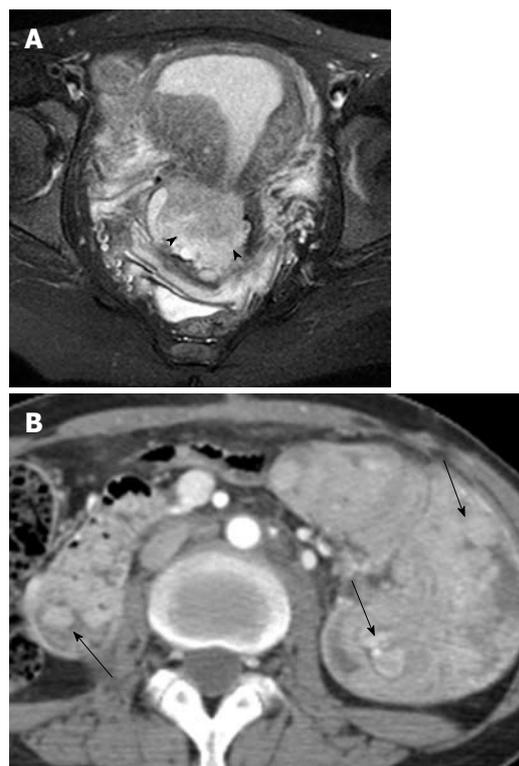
Adenoma malignum of the cervix in a 30-year-old woman with Peutz-Jeghers syndrome. A: Axial T2-weighted MR image shows a multicystic lesion with a solid component (arrowheads) in the uterine cervix; B: Contrast-enhanced CT image shows multiple polyps (arrows) in the duodenum and small bowel causing intussusceptions. CT: Computed tomography; MR: Magnetic resonance.
